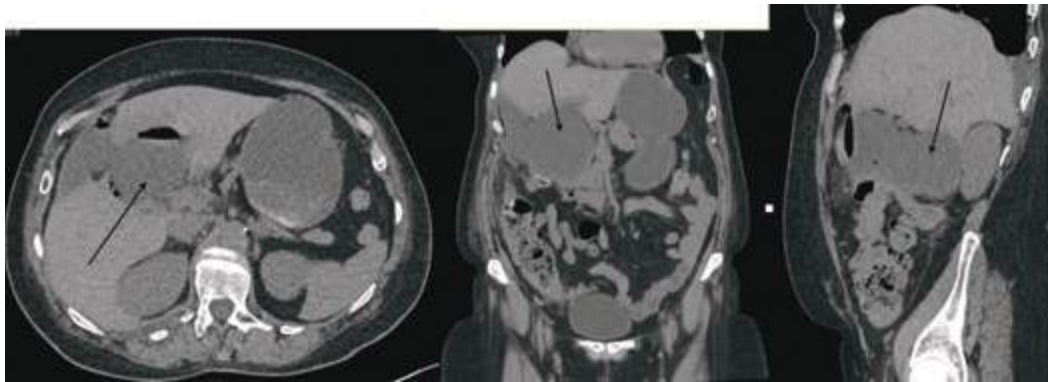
Contrast-enhanced CT images demonstrating a large subhepatic biloma with an air-fluid level (black arrow), consistent with secondary abscess formation. Smaller adjacent collections are also visible.
